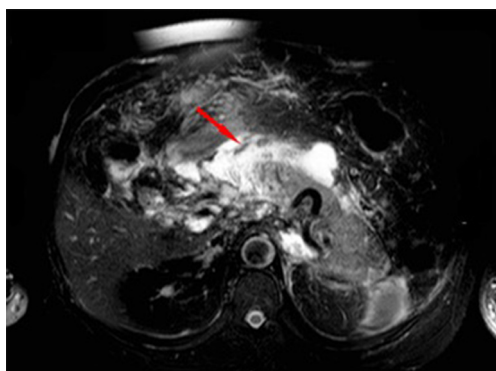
ANC with necrosis of peripancreatic fat tissue (arrow) in unenhanced axial magnetic resonance T2-w image with fat suppression. ANC, acute necrotic collections; T2-w, T2-weighted.
